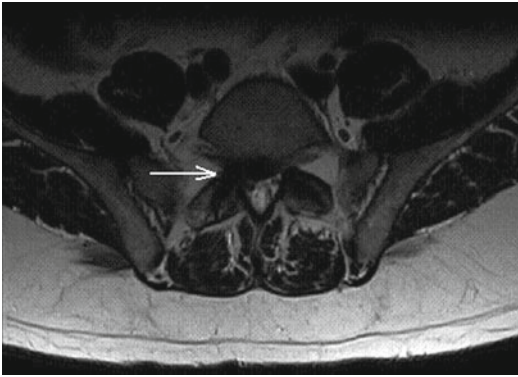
A T2-weighted axial MRI of the lumbar spine demonstrating a posterolateral disk herniation (*arrow*) at the L5–S1 segment completely obliterating the traversing right S1 nerve sleeve
